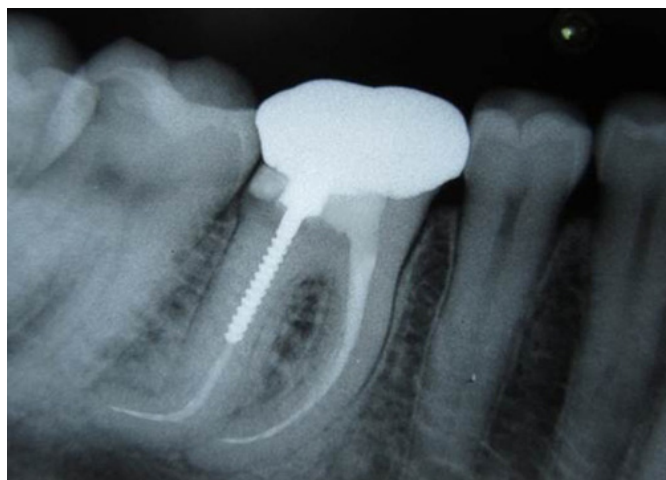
Intraoral periapical radiograph showing complete obturation of dilacerated canal with post and final restoration.
